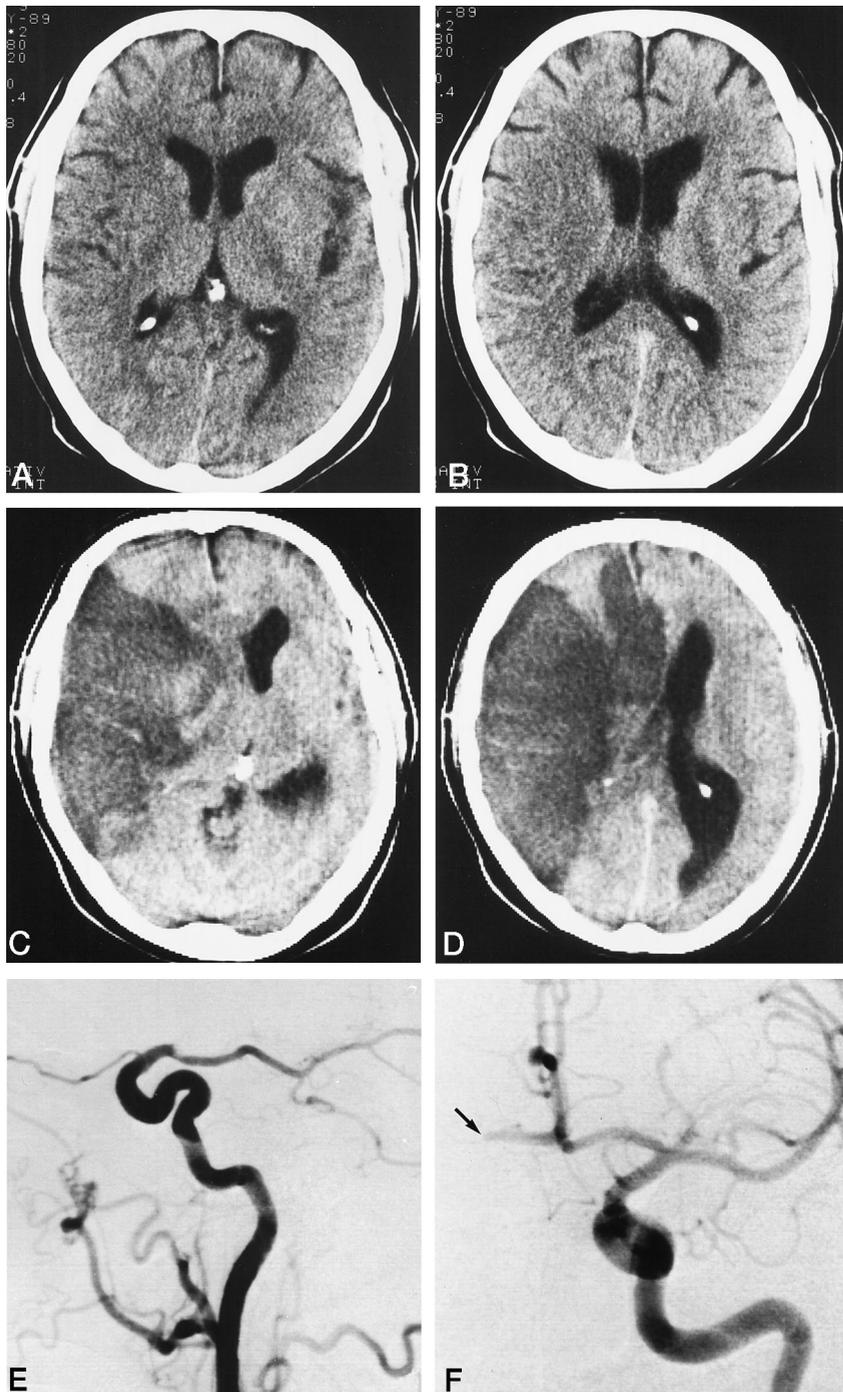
A and B, Initial CT study of a patient with left-sided hemiplegia and impaired level of consciousness lasting 105 minutes shows hypodensity of the lentiform nucleus, insular ribbon, and temporal hemispheric cortex on the right.
